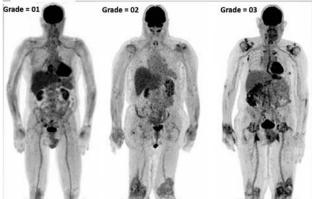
A: ¹⁸FDG PET/CT MIP images in 03 different patients with GCA showing Grade 1-3 uptake. B: ¹⁸FDG PET/CT MIP images in 03 different patients with PMR showing Grade 1-3 uptake in periarticular soft tissue (also variable grade vascular uptake due to associated GCA in these patiengts).
